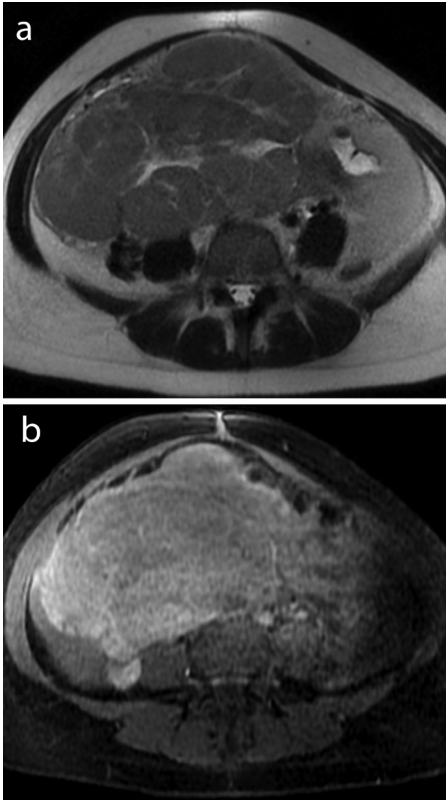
A 22-year-old female was diagnosed with bilateral ovarian dysgerminoma and peritoneal and lymphatic dissemination. Axial T1WI (a) and axial T2WI (b) show large, multilobulated, heterogeneous bilateral tumor, with septa of low-SI on T1WI and T2WI (thin arrows, a, b), some of them associated with edematous component. Hemorrhagic areas with high-SI on T1WI are observed (arrowhead, a), as well as multiple cystic areas, low-SI on T1WI and high-SI on T2WI (thick arrows, a, b). Axial gadolinium-enhanced image (c) revealing heterogeneous contrast enhancement of the tumor, with several enhancing and thickened septa (thin arrows). Axial and coronal T2WI (d, e) also reveal exuberant peritoneal metastases (asterisks). Note the presence of metastases in the left abdominal wall, anterior to the abdominal wall muscles, which were externalized through the entrance port of diagnostic laparoscopic surgery (stars, a, b, e). T1WI, T1-weighted imaging; T2WI, T2-weighted imaging; SI, signal intensity.
